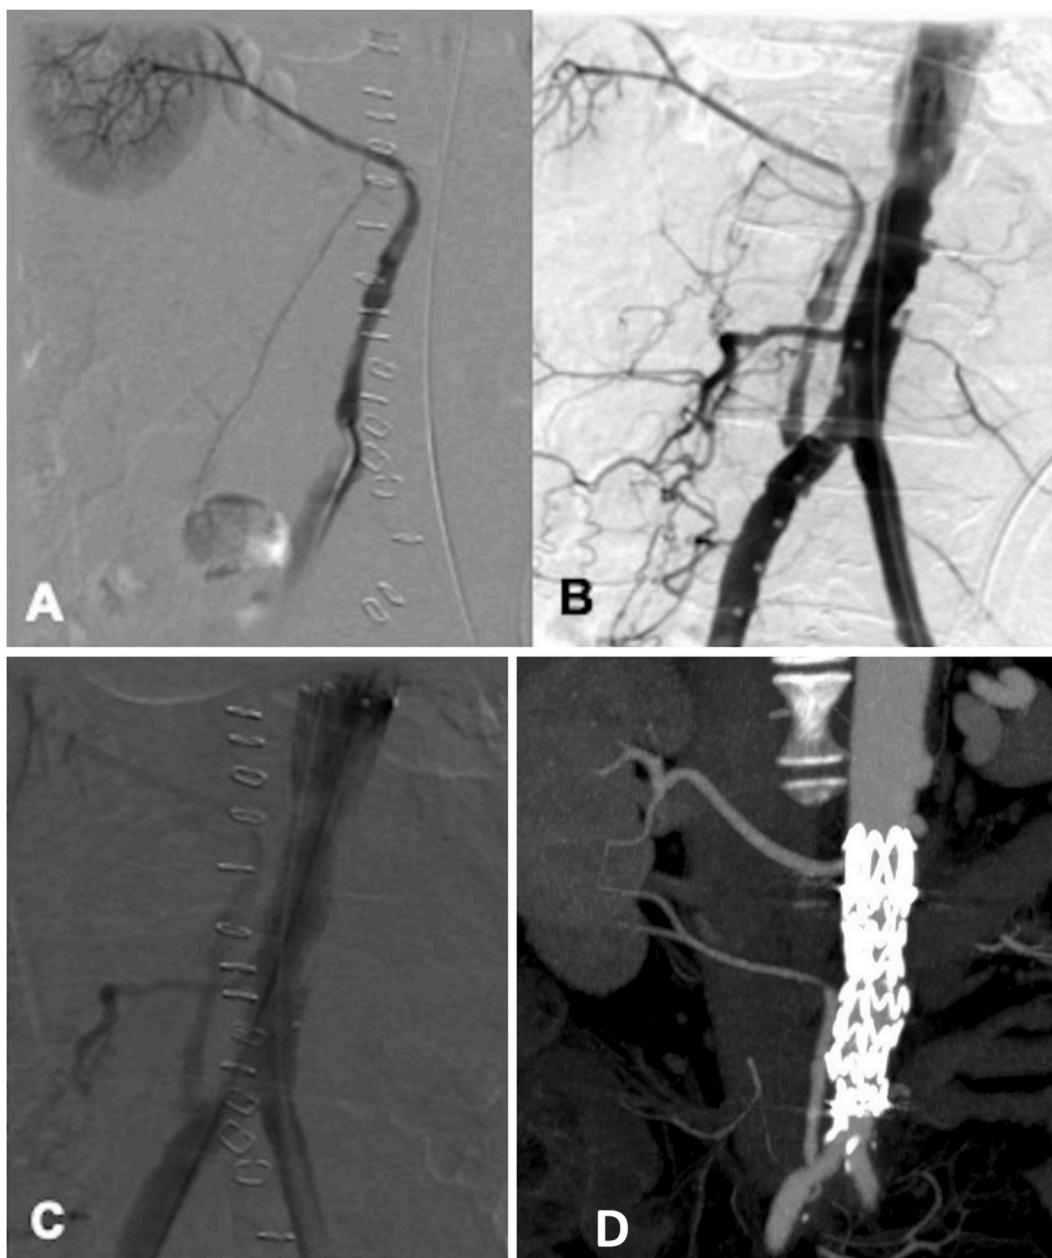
(a,b,c) Through percutaneous right transfemoral access, the AAA was excluded by positioning of an abdominal straight stent graft; (d) One-year follow-up CT scan showed no local or distant recurrence of malignancy, complete exclusion of the AAA and the patency of the renal bypass.
